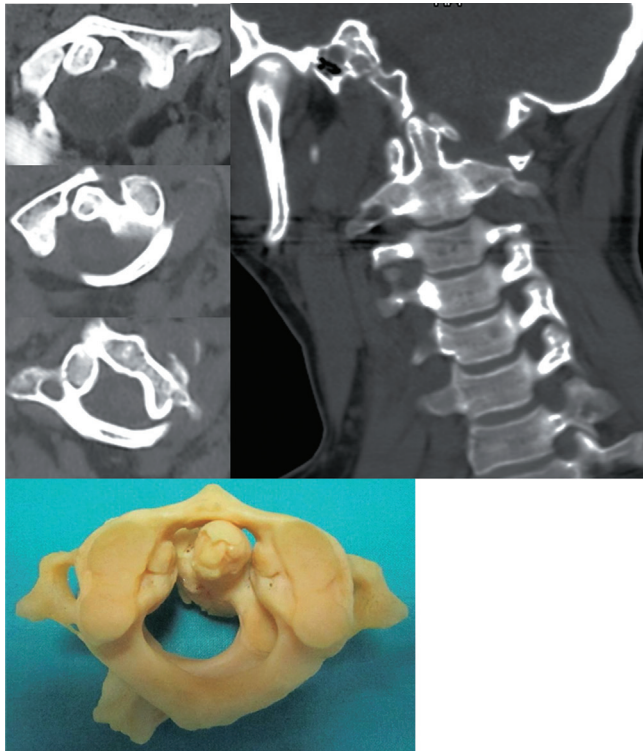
Computed tomography scan and model reconstruction show the Atlanto Axial Rotatory Fixation.
